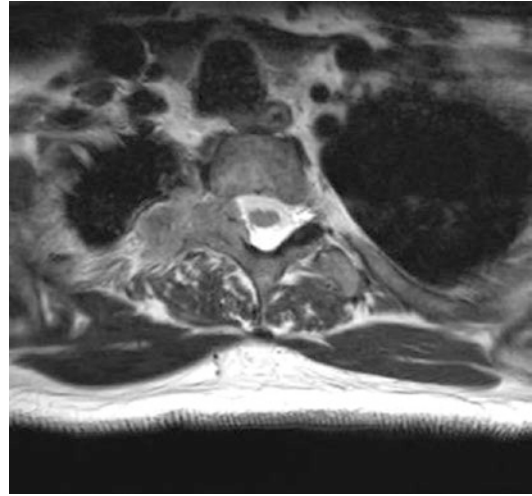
Right-apical mesothelioma along the posterior medial aspect with direct invasion into the spinal canal demonstrated on an axial T2-weighted MR image (arrow); note invasion and displacement of the thecal sac (arrowhead)
